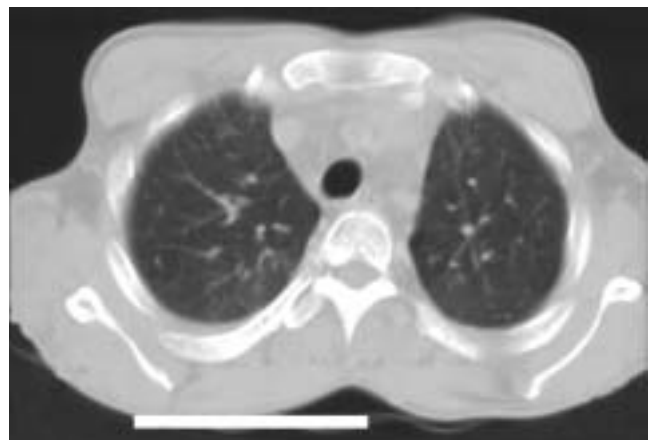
Apical Chest CT scans without significant pathologies.
